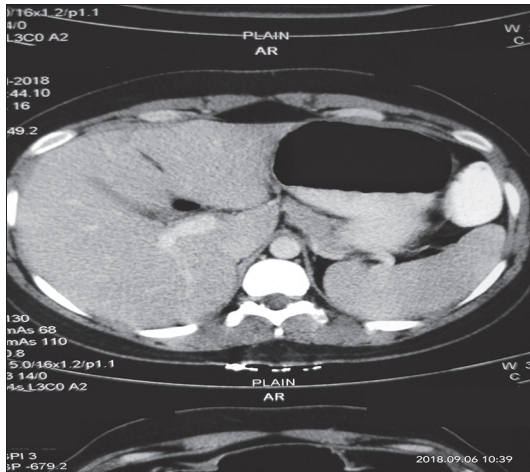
Contrast-enhanced computed tomography abdomen showing a well-defined smoothly marginated soft-tissue density submucosal lesion around the antrum and pylorus of the stomach
